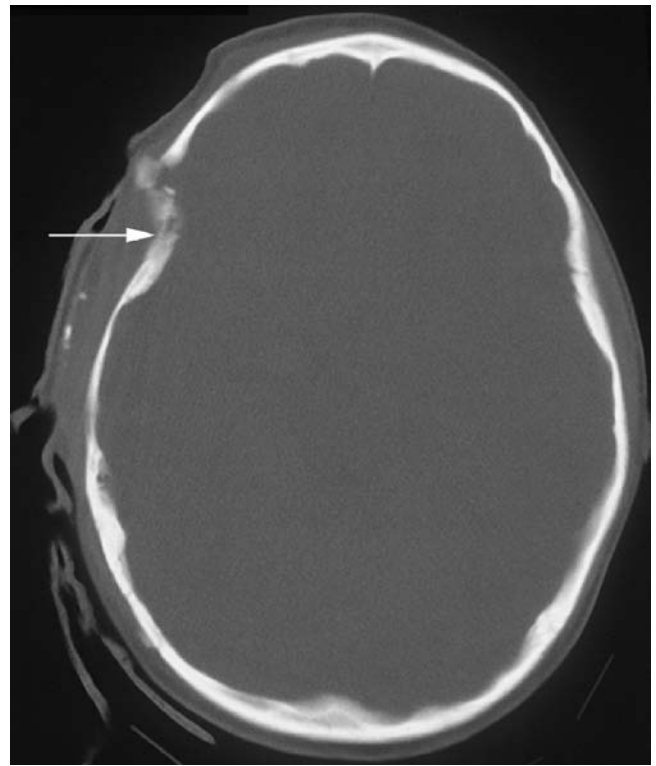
Depressed skull fracture. This head computed tomographic scan was performed on a 6-year-old boy who was unresponsive and apneic after being a passenger in a high-speed motor vehicle collision. The *arrow* indicates a depressed skull fracture involving the right temporal bone. He also had an associated right temporal contusion (Fig. 116.7).
